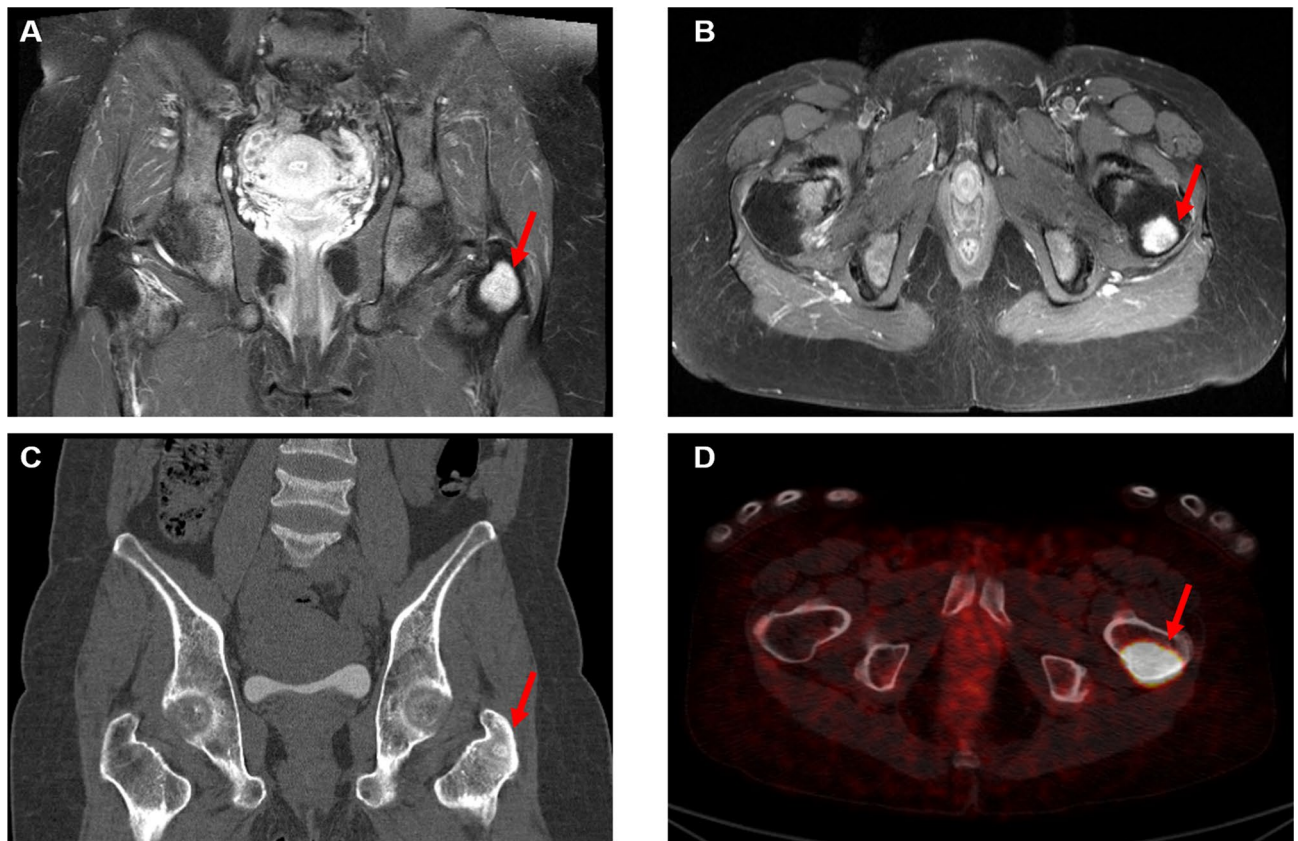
A representative case showing the specificity and strength of ^{68}Ga -DOTATOC PET/CT as compared to conventional images. A 48-year-old woman suspected of TIO had pelvic CT and MRI 10 years before undergoing the ^{68}Ga -DOTATOC PET/CT because of hip pain. The images showed a well-enhancing mass-like sclerotic lesion in the left femur, which was in the greater trochanter in the coronal, axial enhanced pelvic MRI (A,B) and coronal non-enhanced pelvic CT images (C). However, the lesion was considered a hematopoietic marrow or Brown tumor at that time rather than a primary bone tumor. Ten years later with ^{68}Ga -DOTATOC PET/CT image (D), the lesion showed slowly grown tumorous features with intense radiotracer uptake strongly suggesting the culprit tumor for osteomalacia. Subsequent bone biopsy favored the presence of a phosphaturic mesenchymal tumor.
